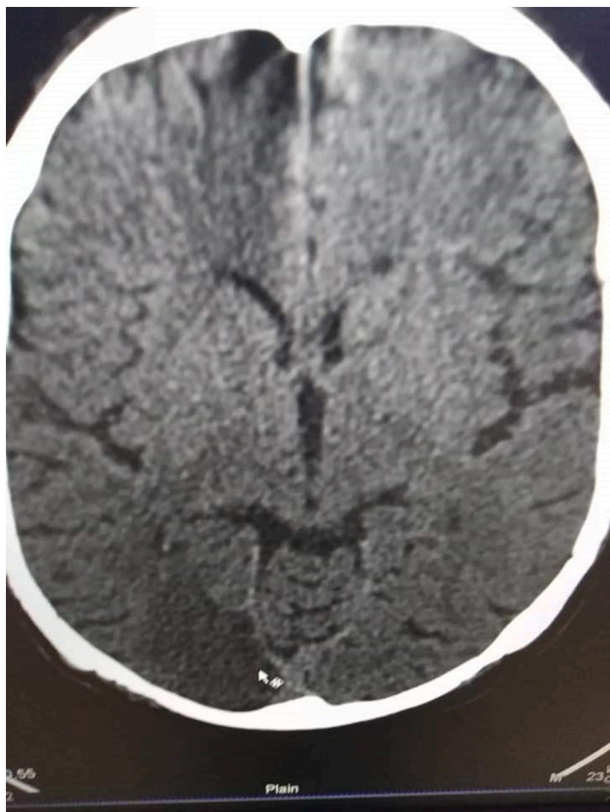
Computed Tomography of the brain shows right occipital lobe infarction.
